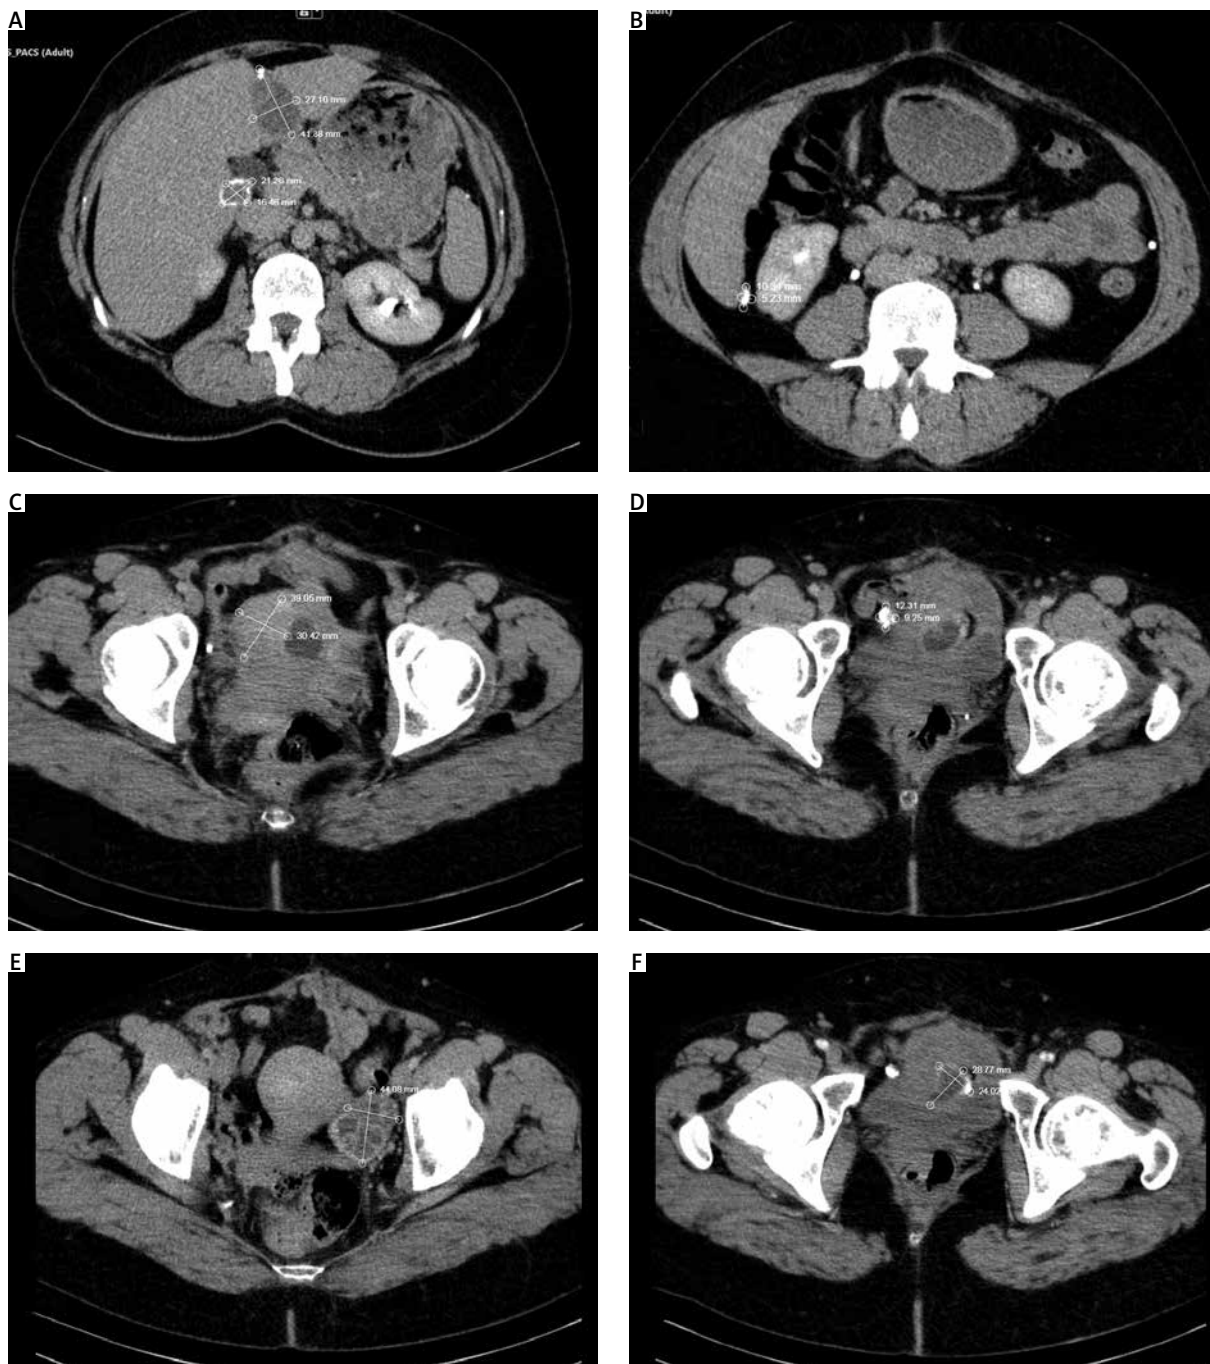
Computed tomography scan findings: old hepatic echinococcal cysts – at the border of the left/right liver lobe a separated cystic lesion, in places with calcium inclusions in the wall 42/27 mm and in the right lobe paracaval devitalized echinococcal cyst 21/16 mm (A), calcifications subcapsular 10/5 mm (B), intramural fibroid node 39/30 mm (C), lesion with calcium density in the right parauterine 12/9 mm (D), in the area of the left ovary, a hyperdense, separated lesion with calcium deposits 44/31/41 mm (E), cyst formation in the uterine wall 29/24 mm (F)
